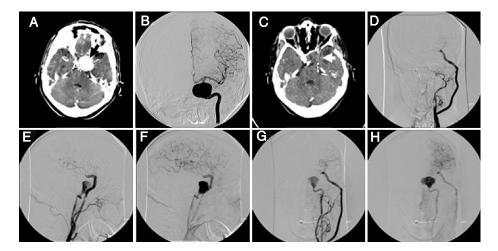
These are the images of a 56 year old lady who presented with a cavernous sinus syndrome on the left side. Her contrast enhanced CT scan (A: arrow demarcated aneurysm) and cerebral angiogram (B) revealed a left sided intracavernous aneurysm which was treated with ECA-M2 bypass followed by balloon occlusion 4 days following surgery. The flow into the aneurysm stopped immediately following the balloon occlusion (D), and the aneurysm was noted to remain obliterated on the 3 month contrast enhanced CT scan (C). These images also demonstrate balanced flow in the graft and the internal carotid on a common carotid injection (E–H). This argues against concerns expressed by a number of surgeons who maintain that early/immediate closure of the parent vessel is necessary to encourage flow in the graft
